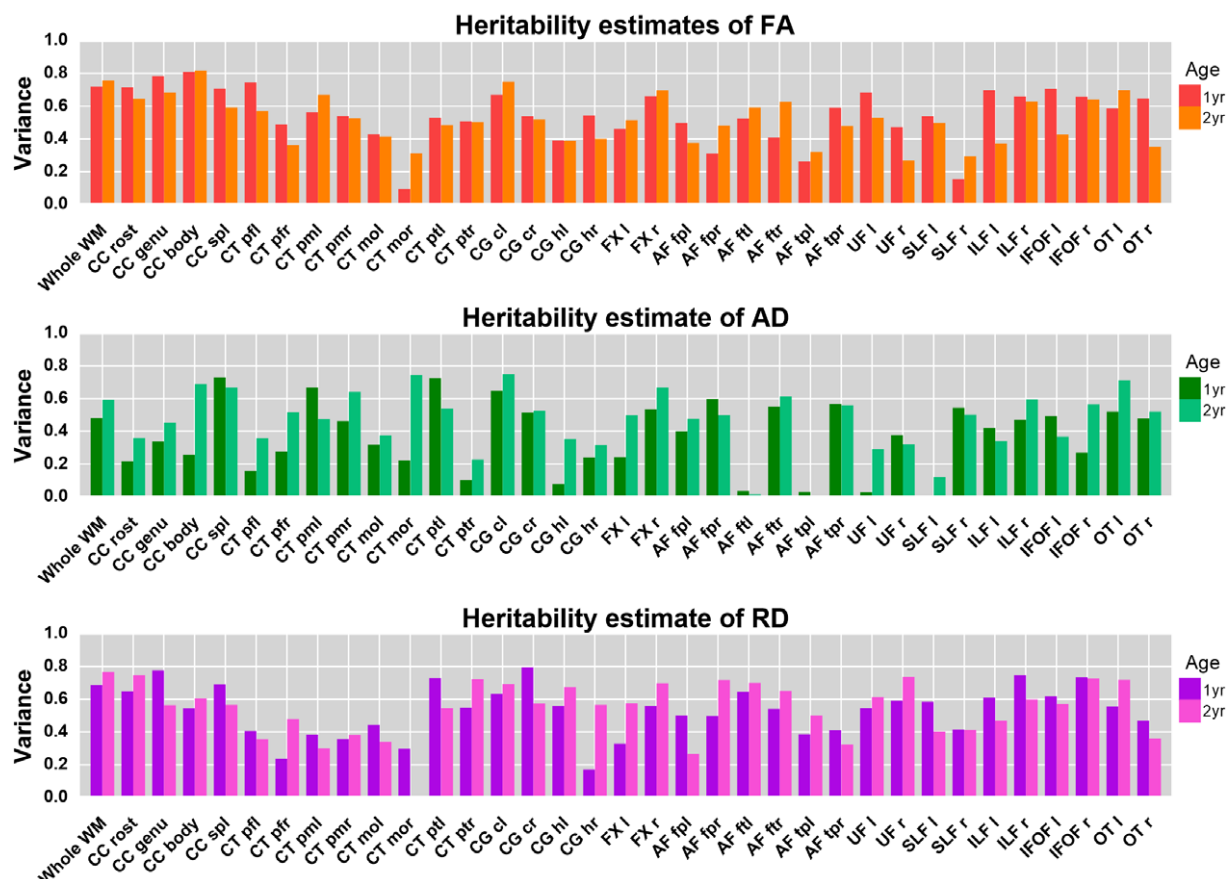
Genetic estimates of whole and individual tract-averaged FA, AD, and RD in 1 and 2 years old. Abbreviations: Rostrum (rost), genu, body, and splenium (spl) of corpus callosum (CC); left (l) and right (r) prefrontal (pf), premotor (pm), motor (mo), and parietal (pt) projections of the corticothalamic tract (CT); cingulate (c) and hippocampal (h) cinguli (CG); fornices (FX); frontoparietal (fp), frontotemporal (ft), and temporoparietal (tp) parts of arcuate fasciculi (AF); uncinate fasciculi (UF); superior and inferior longitudinal fasciculi (SLF and ILF); inferior fronto-occipital fasciculi (IFOF); and optic tracts (OT)
